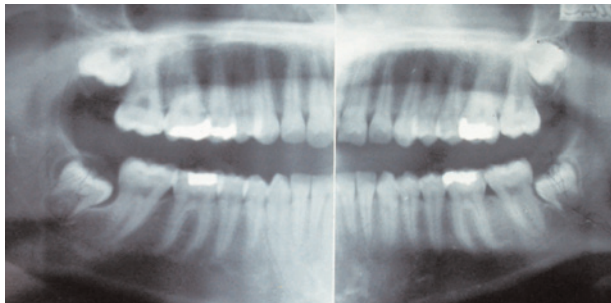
Panographic radiograph of 4 normally developing wisdom teeth, classified as full bony impactions at the time of extraction.
